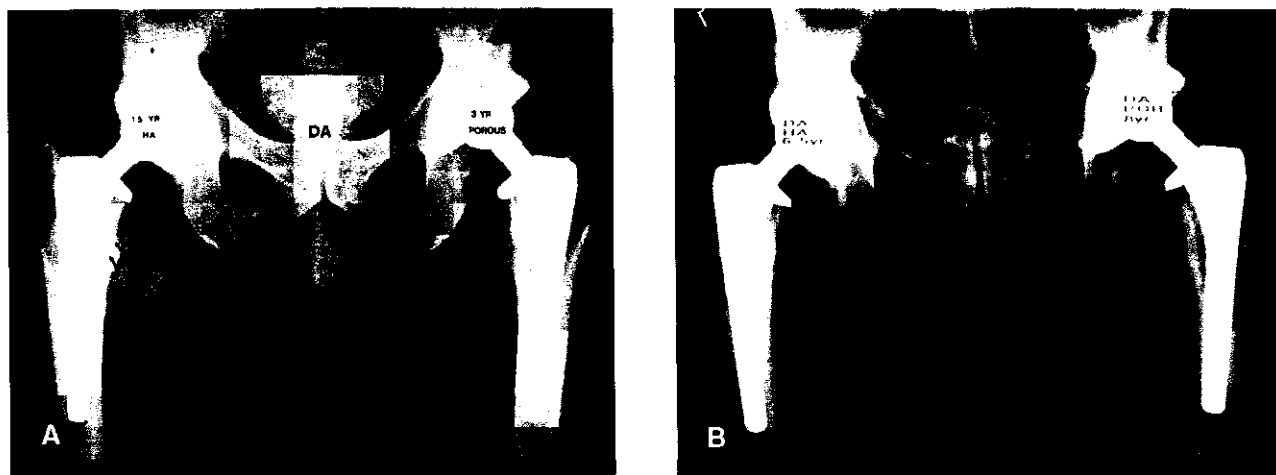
(A) Radiograph of bilateral total hip arthroplasties. The right hip has a hydroxyapatite-coated stem, which shows dense medial cancellous hypertrophy in zone 7 at 1.5 years. The left hip is porous-coated-only stem without medial or lateral cancellous hypertrophy. (B) Same hips 5 years later, which show extension of medial endosteal bone remodeling into zone 6. There is development of a pedestal at the tip of the left hip, which is the porous-only stem.
